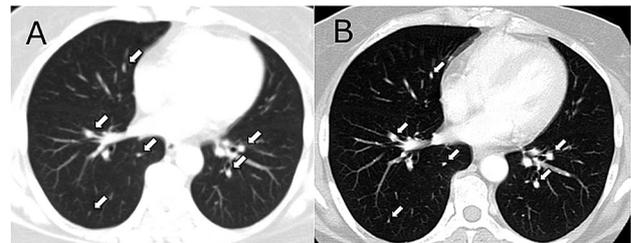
Chest CT examination: (A) pre-operation (B) post-operation. Multiple small cysts (arrows) permeate the entire lung parenchyma, indicating pulmonary LAM.
